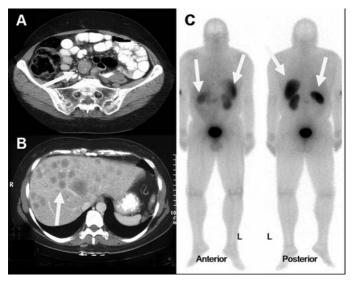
Abdomen and pelvic computed tomography scan showing an enlarged lymph node (*arrow*) of a patient whose primary small bowel tumor could not be localized (A) but whose multiple liver metastases are well visualized (B). Somatostatin receptor scintigraphy, a more sensitive and specific radiologic technique for carcinoid tumors, reveals a large tumor burden in the liver as well as a primary small bowel tumor (C).
